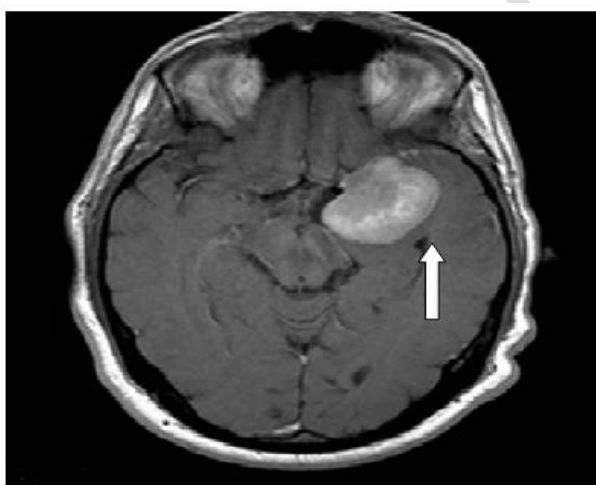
Lt sided sphenoid wing meningioma visualized in axial and coronal T₁ post contrast. MRI.
